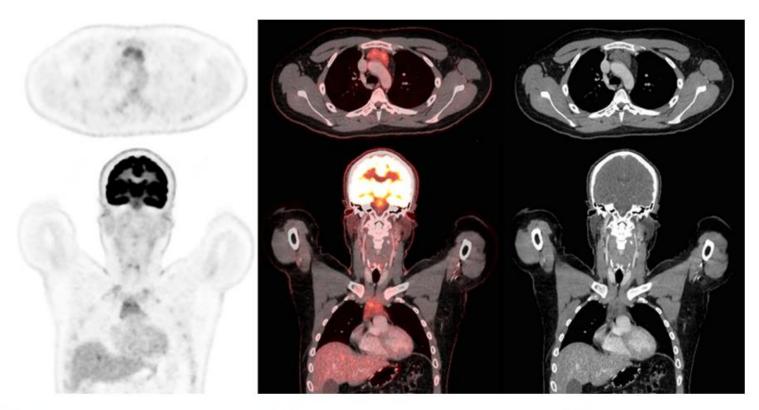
Transverse and coronal slices of FDG-PET/CT, fusion and CT in a 22- year-old male patient with common variable immune deficiency and weight loss in whom malignant disease needed to be excluded. FDG-PET/CT showed moderately to strongly increased FDG-uptake in the anterior mediastinum, representing thymus hyperplasia. This physiological entity is a pitfall of FDG-PET imaging and should not be interpreted as a malignant finding. No malignant lesions were detected in this patient.
